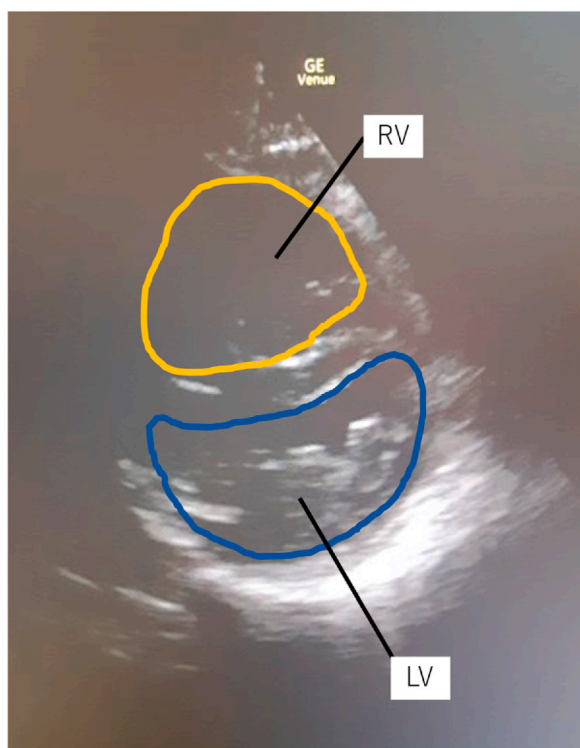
Ultrasound cardiography from the short-axis view shows a D-shaped left ventricular (LV) cavity alongside a grossly hypertrophied right ventricle (RV).
